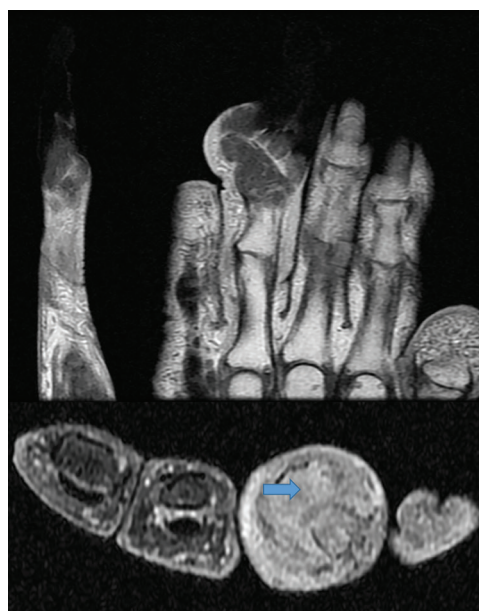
MRI images showing the lesion with bony destruction
